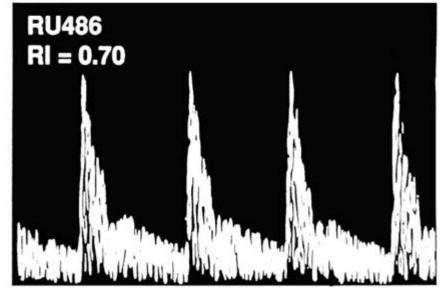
Doppler ultrasonography of uterine arterial flow velocity waveforms before (top) and after RU 486 treatment (bottom) in a patient with uterine leiomyoma (RI = resistance index).
